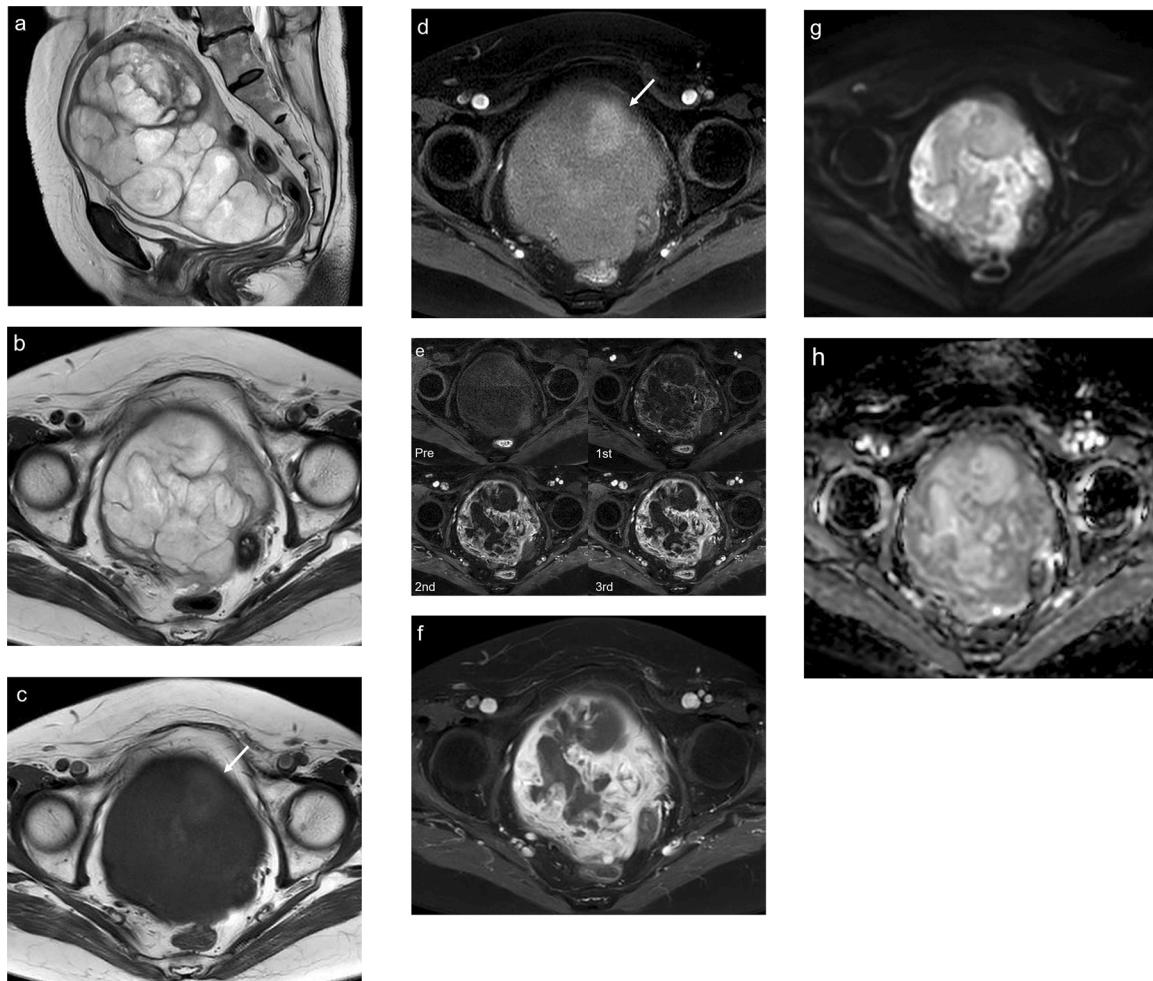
Magnetic resonance imaging (MRI).
